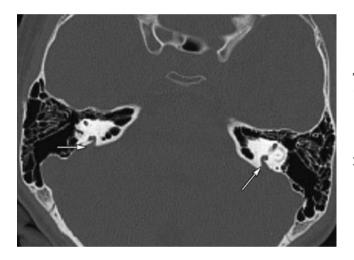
CT scan of bilateral aqueduct vestibule expansion (arrow)
